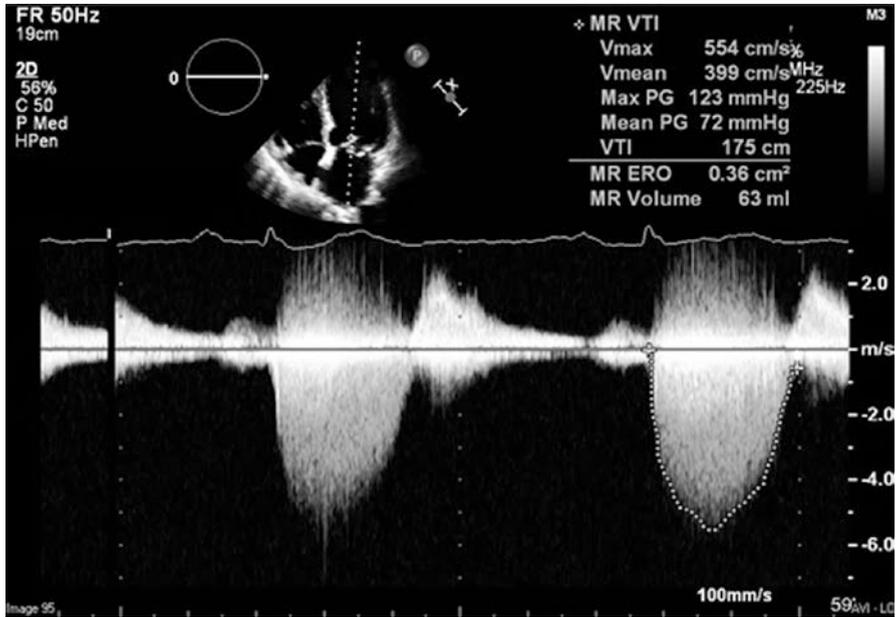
Continuous wave Doppler sampled across the mitral valve
